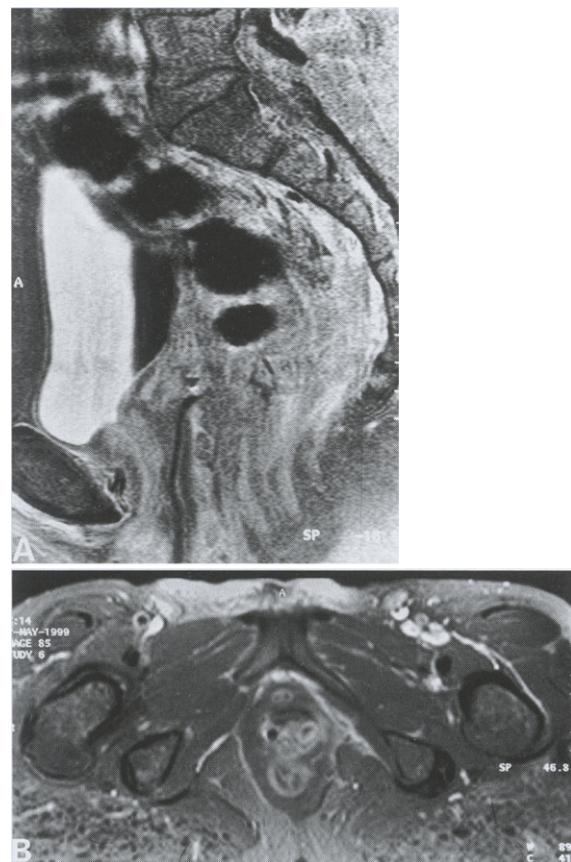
(A) Transverse and (B) coronal MRI, showing a well-described mass with central necrosis.
